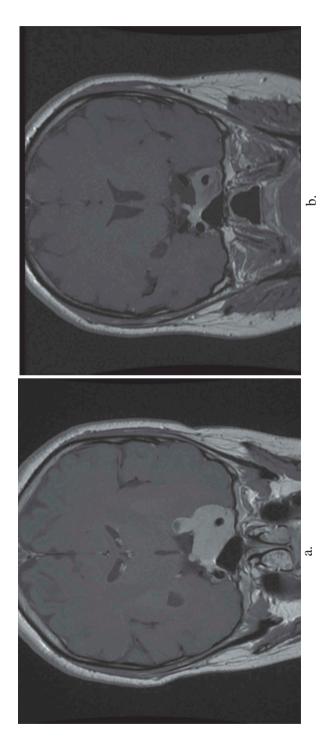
MRI aspect of a DA-resistant macroprolactinoma in a 33-year-old patient. [A] Before cabergoline (CAB) introduction, the patient was diagnosed with left diplopia and erectile dysfunction. Hormonal analysis revealed a prolactin (PRL) level up to 4800 ng/mL. [B] MRI after 12 months of CAB therapy. Posology increased gradually from 0.5 to 3 mg/week at the last follow-up. PRL decreased to 1200 ng/mL, but never reached the normal range and tumor volume shrinkage was considered to be less than 50% from the initial tumor volume. Interestingly, diplopia spontaneously resolved 3 weeks after the initiation of CAB therapy.
